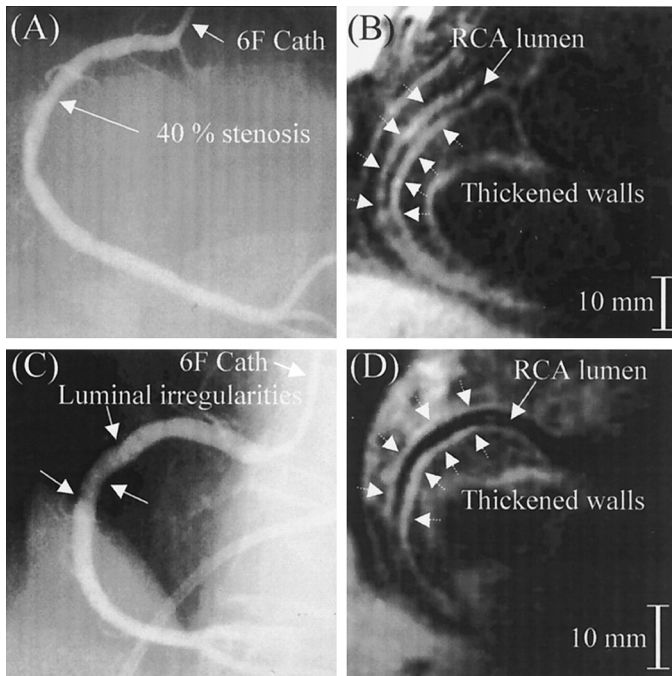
Black-blood 3D CMR vessel wall scans (B, D) demonstrate an irregularly thickened RCA wall (>2 mm) indicative of an increased atherosclerotic plaque burden. The inner and outer RCA walls are indicated by the white dotted arrows. Comparison is made with the corresponding diagnostic x-ray angiographic images (A, C). (Figure reproduced from: Reference 67, Kim WY, Stuber M, Börner P. Three-dimensional black-blood cardiac magnetic resonance coronary vessel wall imaging detects positive arterial remodelling in patients with non-significant coronary artery disease. (*Circulation* 2002; 106: 296. Reproduced with permission of the publishers.)
